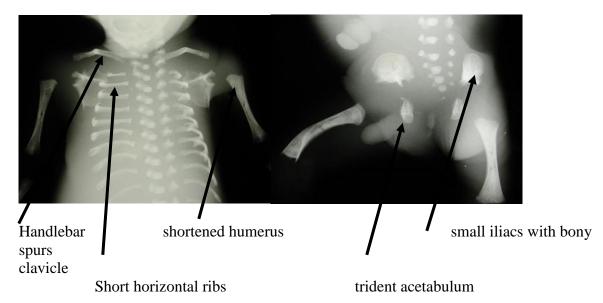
The skeletal features of JATD. The x-rays are of proband C1 with the skeletal manifestations marked by arrows. The X-ray was taken in the initial clinical investigation of the child and reviewed by Dr C Hall, radiologist, to confirm the skeletal features of JATD. Parents of C1 consented for the use of the x-ray for research.
